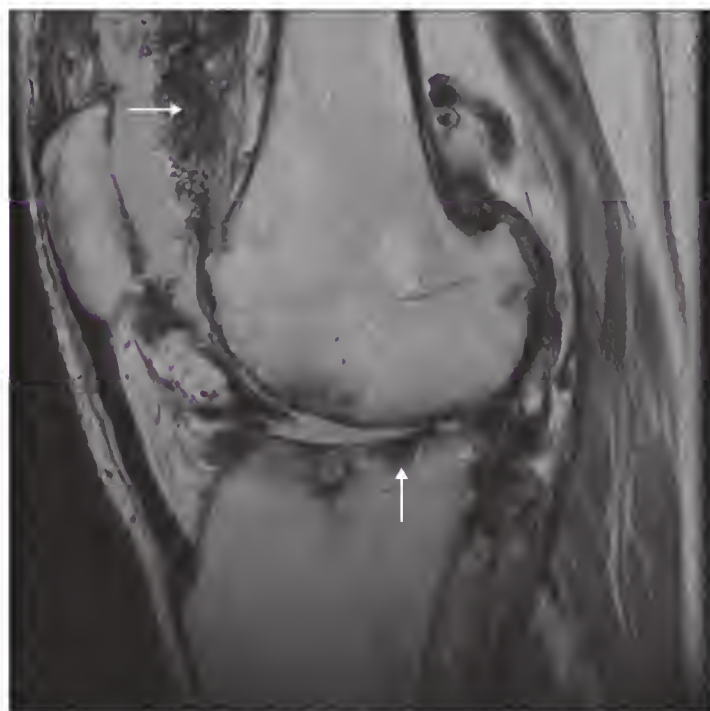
Hemophilic arthropathy of the knee seen on a sagittal proton density-weighted magnetic resonance image. Extensive synovitis of very low signal intensity is present in the suprapatellar recess, consistent with hemosiderin from recurrent hemarthroses (horizontal arrow). In addition, full thickness cartilage loss and subchondral cysts are evident in the lateral compartment of the knee (vertical arrow).
